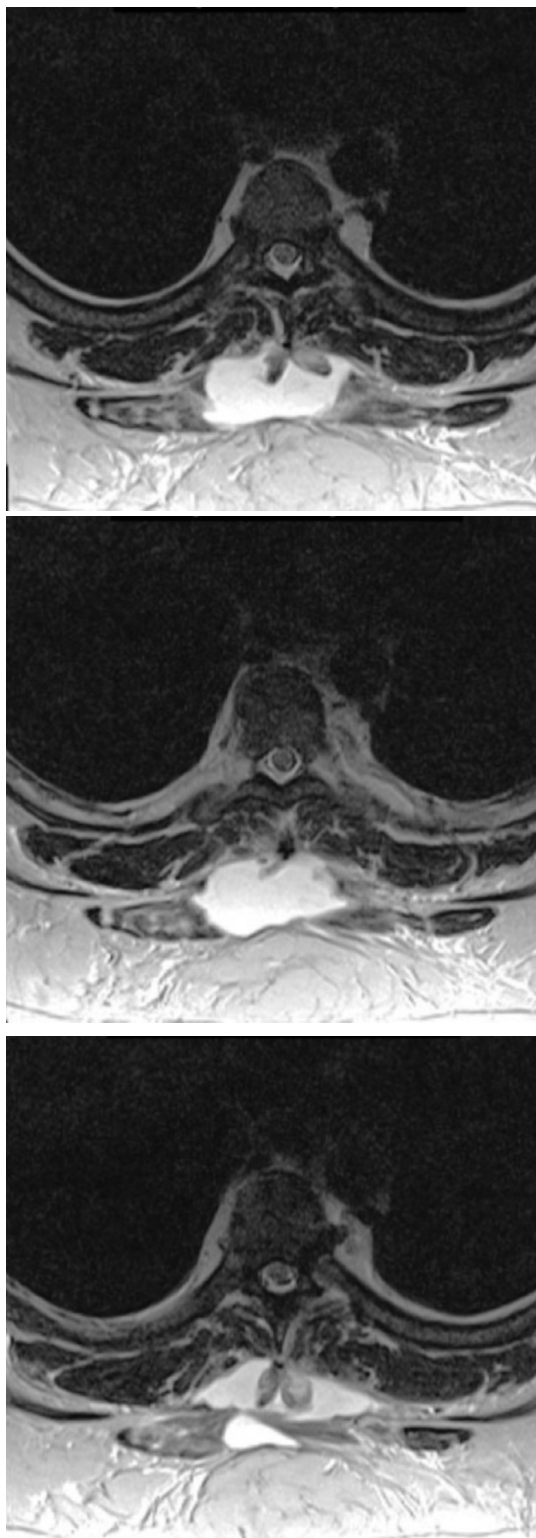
Three adjacent, axial, T2-weighted MR images show retraction of the trapezius muscles from the spinous processes with surrounding hematoma. There are areas of nodularity within the fluid collection that represent torn fragments of muscle.
